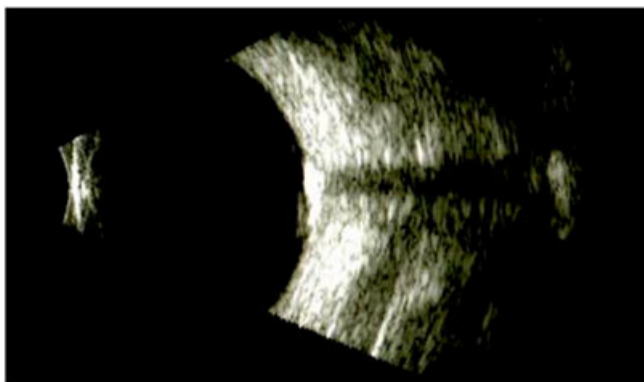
B-scan ultrasonography demonstrating a hyperechogenic mass (hamartoma) with posterior shadowing due to calcifications.
